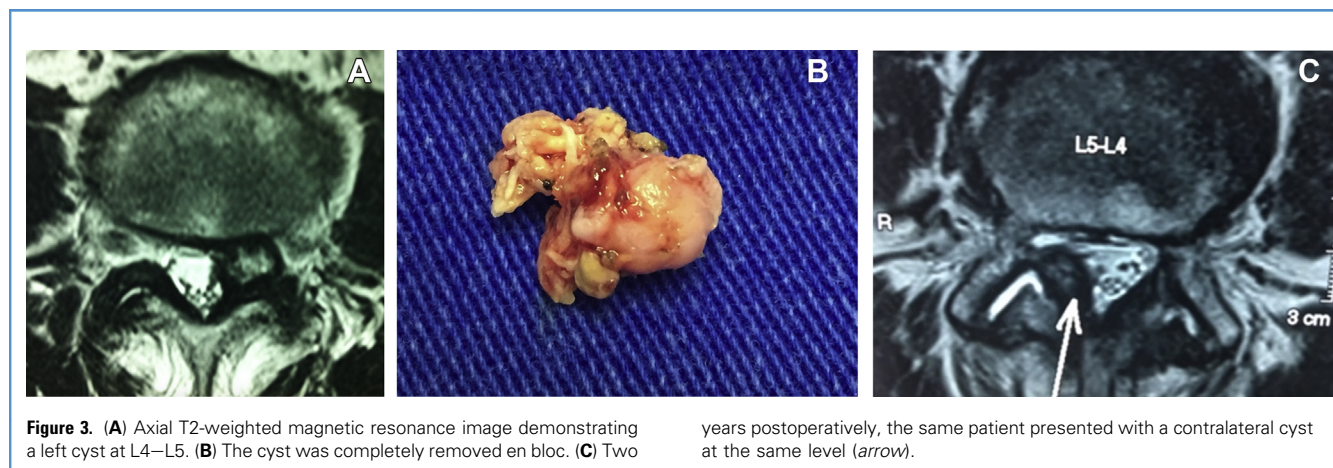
(A) Axial T2-weighted magnetic resonance image demonstrating a left cyst at L4–L5. (B) The cyst was completely removed en bloc. (C) Two
